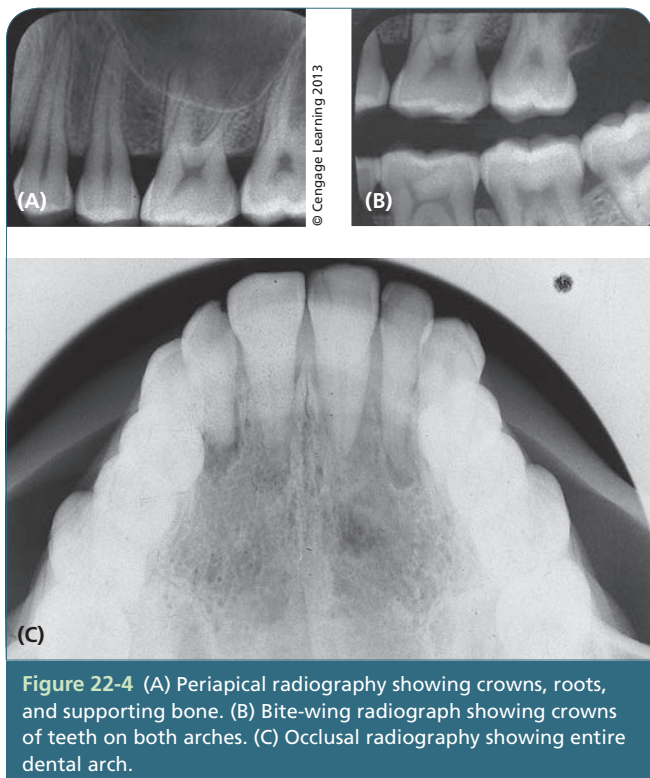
(A) Periapical radiography showing crowns, roots, and supporting bone. (B) Bite-wing radiograph showing crowns of teeth on both arches. (C) Occlusal radiography showing entire dental arch.
